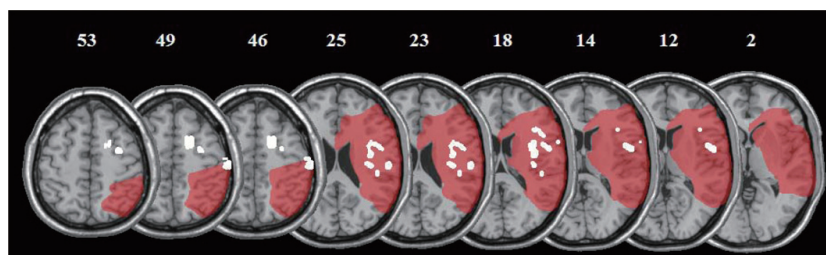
In red, the lesion of CT, the patient showing also an extensive cortical damage, mapped in the stereotactic space and superimposed on brain regions (in white) involved in AHP [24]. In spite of the large cortical lesion, it is clear the sparing of some of the brain areas associated with AHP by Berti et al. [24].
